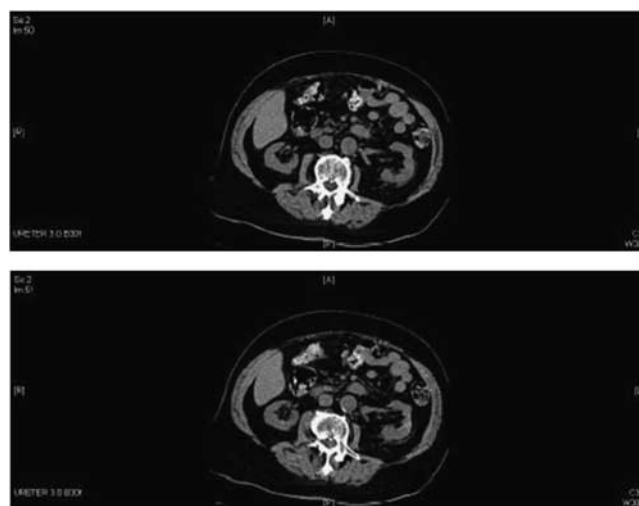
CT scan of abdomen showing small indented, calcific kidneys (SICK), a finding that is associated with analgesic nephropathy. Using the classification proposed by Elseviers *et al.*¹ this corresponds to stage III disease.
